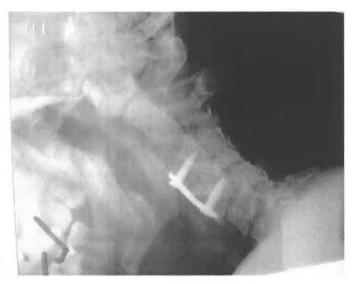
X-Ray of the cervical region, segital view
